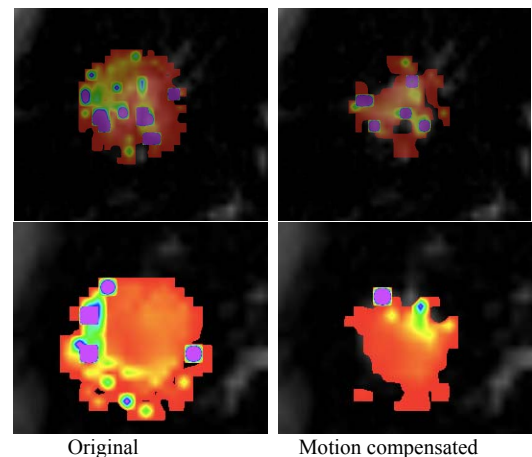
Distributions map of K^{trans} around SPN region are calculated from original (left) and motion-corrected (right) DCE MRI for two cases (upper and lower) and mapped to the structural MR images. The K^{trans} map calculated from original DCE MRI does not match to the actual SPN area.
